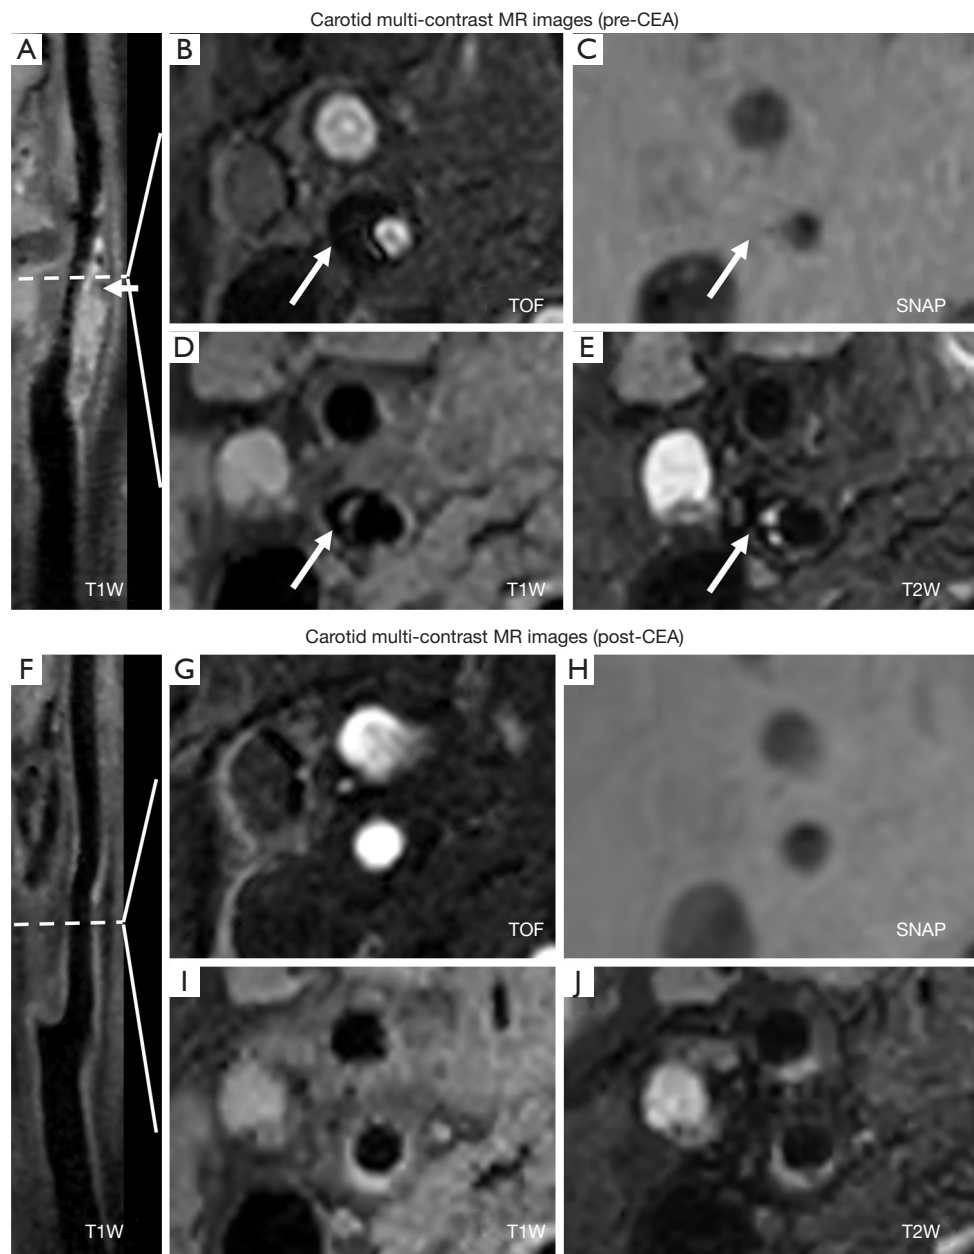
A 76-year-old male patient had a calcific plaque in the right internal carotid artery and underwent revascularization pre- and post-CEA. The patient's scores of pre-MoCA and post-MoCA were 17 and 20, respectively. Calcification can be seen in the multi-contrast MR images (white arrows). (A) 3D T1W curved planar reconstruction image before CEA; (B) 3D TOF image before CEA; (C) SNAP image before CEA; (D) 2D T1W image before CEA; (E) 2D T1W image before CEA; (F) 3D T1W curved planar reconstruction image after CEA; (G) 3D TOF image after CEA; (H) SNAP image after CEA; (I) 2D T1W image after CEA; and (J) 2D T1W image after CEA. CEA, carotid endarterectomy; MR, magnetic resonance; MoCA, Montreal Cognitive Assessment; T1W, T1-weighted; TOF, time-of-flight; SNAP, simultaneous non-contrast angiography intraplaque hemorrhage; T2W, T2-weighted.
